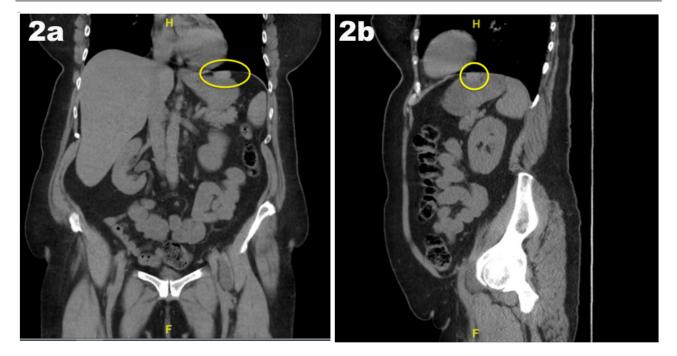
Single coronal and sagittal view of computed tomography scan demonstrating the AV malformation, respectively. The AVM was described as a well-circumscribed soft tissue mass measuring 2.4 cm \times 1.9 cm \times 1.2 cm present adjacent to the stomach and diaphragm
